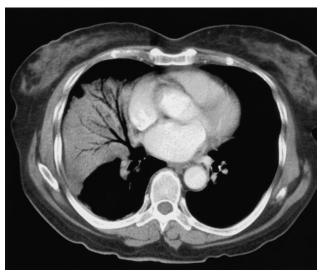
Pneumonia, Right Middle Lobe. Computed tomography slice shows an alveolar filling process in the right middle lobe with tubular air bronchograms running through it. The patient is a 73-year-old woman.
